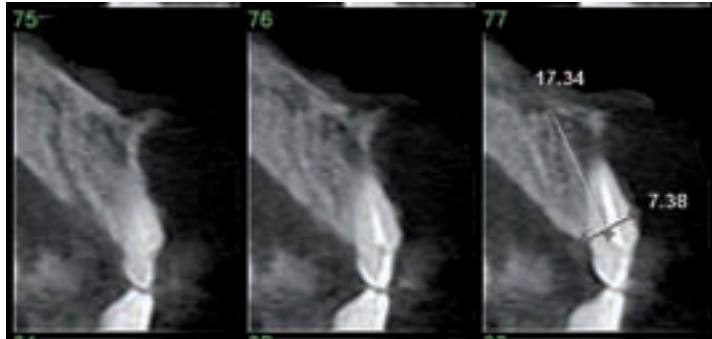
Reformatted cone beam computed tomographic views of an upper left central incisor showing sufficient bone volume on the palatal aspect of the socket to allow an implant to be placed at the time of extraction.
